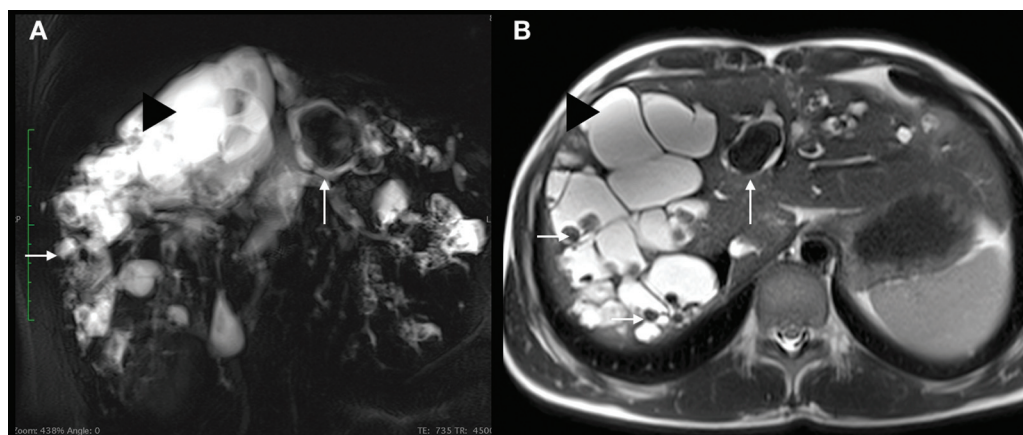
A 16-year-old female with recurrent pain abdomen. Coronal thick slab magnetic resonance cholangiopancreatography (MRCP) (A) and axial T2-weighted (T2W) (B) images showing communicating dilated cysts (black arrowheads) consistent with findings of Caroli disease with multiple hypointense filling defects suggestive of calculi within (white arrows).
